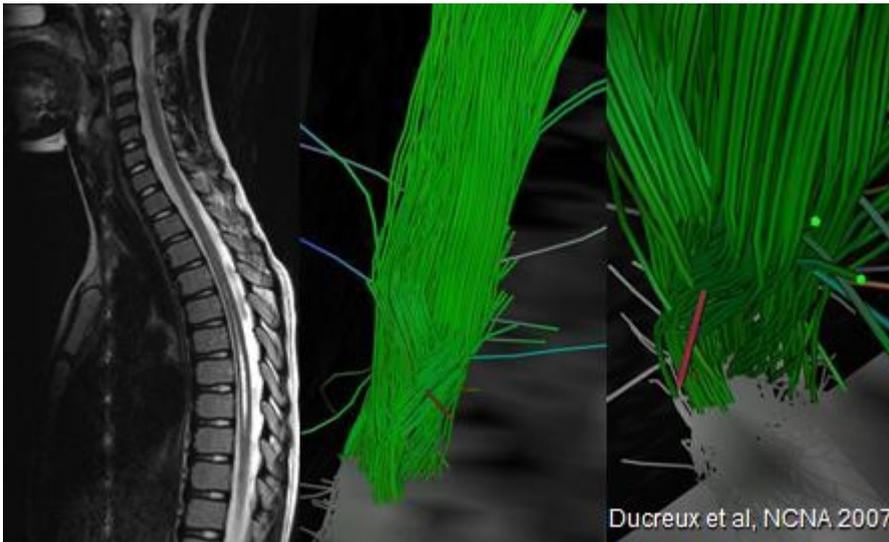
Intramedullary cleft. MRI in sagittal T2 sequence and fibre tracking. Interruption of the fibres on the tracking.
